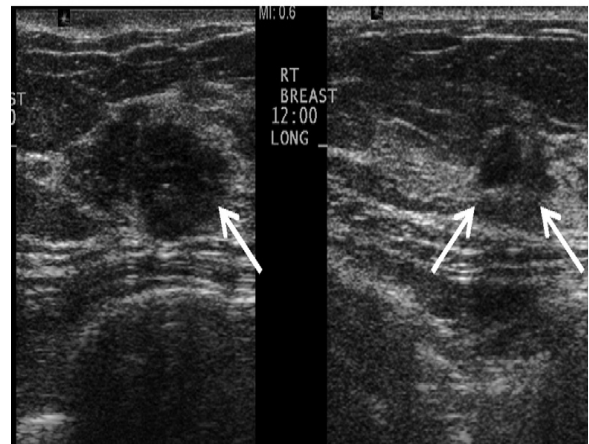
Longitudinal grayscale ultrasound images show two irregular hypoechoic masses (arrows), measuring 1.5 cm and 0.6 cm at the 10- and 12-o'clock positions respectively in the right breast. Ultrasound-guided core needle biopsies revealed intermediate grade ductal carcinoma in situ at both sites [4].
